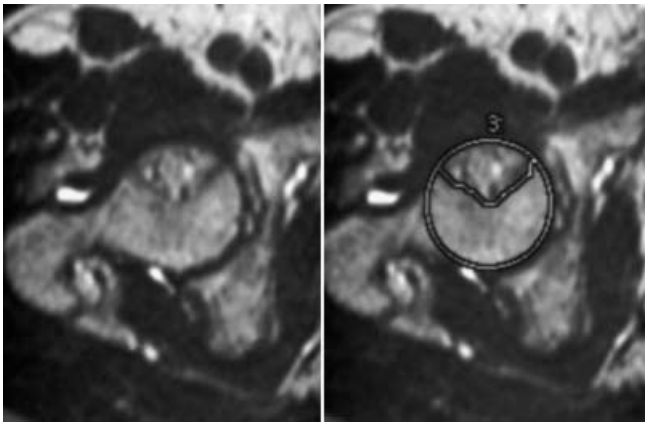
Direct measurement of the necrotic area on MRI scan
